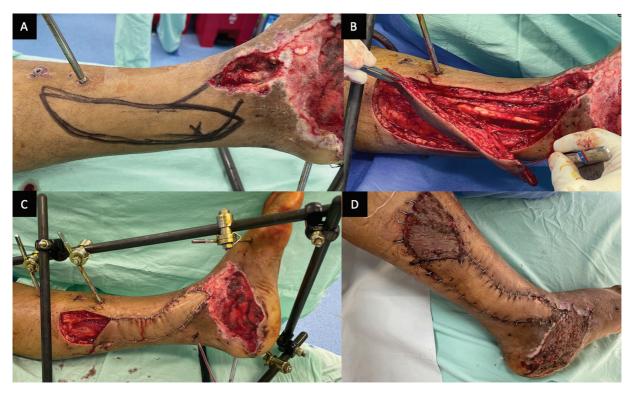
(A) Planning of the propeller flap and identification of the perforating artery with color Doppler. (B) Dissection of the posterior tibial artery (perforator). (C) Propeller flap rotation to cover the defect over the medial malleolus. (D) Follow-up 5 days after partial thickness skin graft coverage of the defect in the medial region of the foot and donor area.
